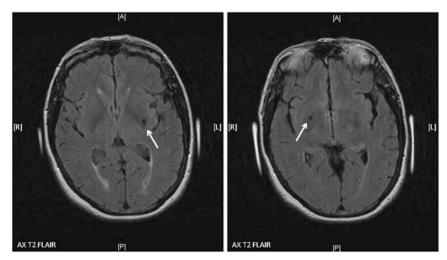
MRI brain showed foci of hyperdensities in the deep white matter and hypodensities in the lentiform nuclei (arrows).
